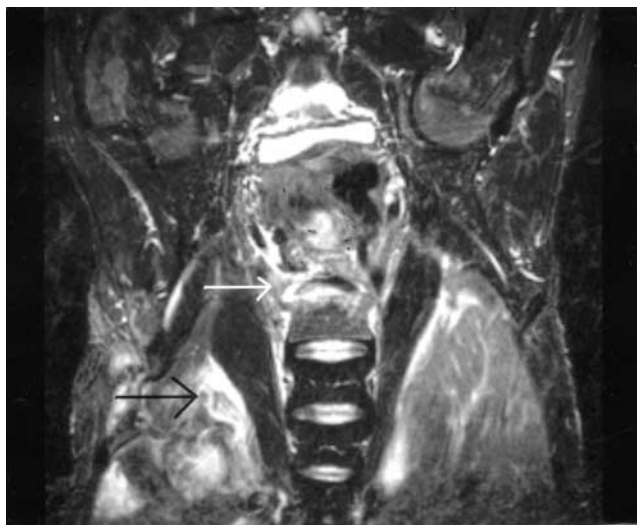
Coronal STIR MRI. High signal lateral to the left psoas muscle indicates inflammation in this area; however, the inflammation is not seen to extend directly into the L5/S1 disc space (black arrow). High signal at the L5/S1 disc space represents discitis (white arrow)
